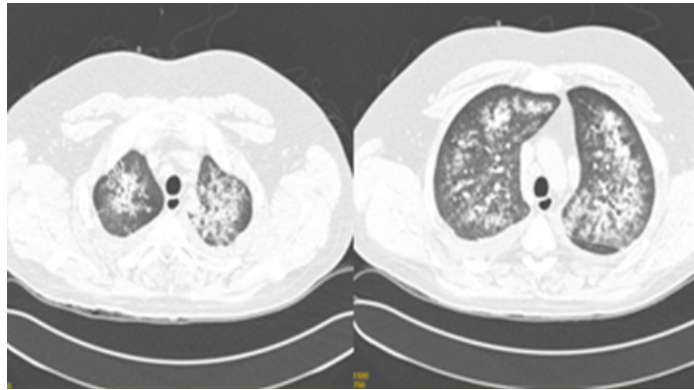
Chest CT: diffuse interstitial and alveolar infiltrate.
